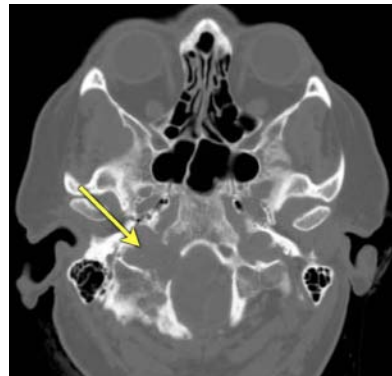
Preoperative CT shows bony erosion of the right hypoglossal canal and jugular foramen
